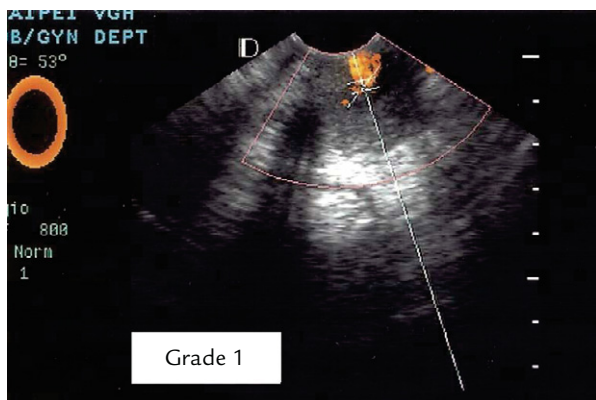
Power Doppler ultrasound shows grade 1 vascularity ($0 < \text{vascular ratio} < 25\%$) within the tumor.
